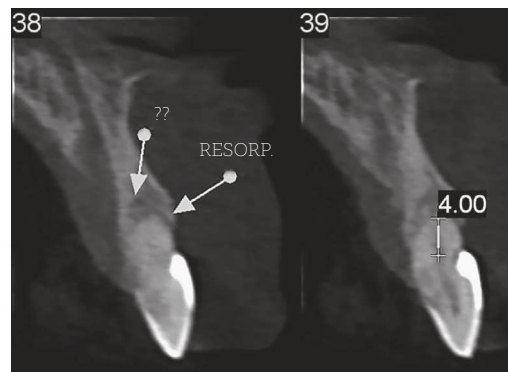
Initial radiograph, performed in 20/02/2011, for posterior follow-up.
